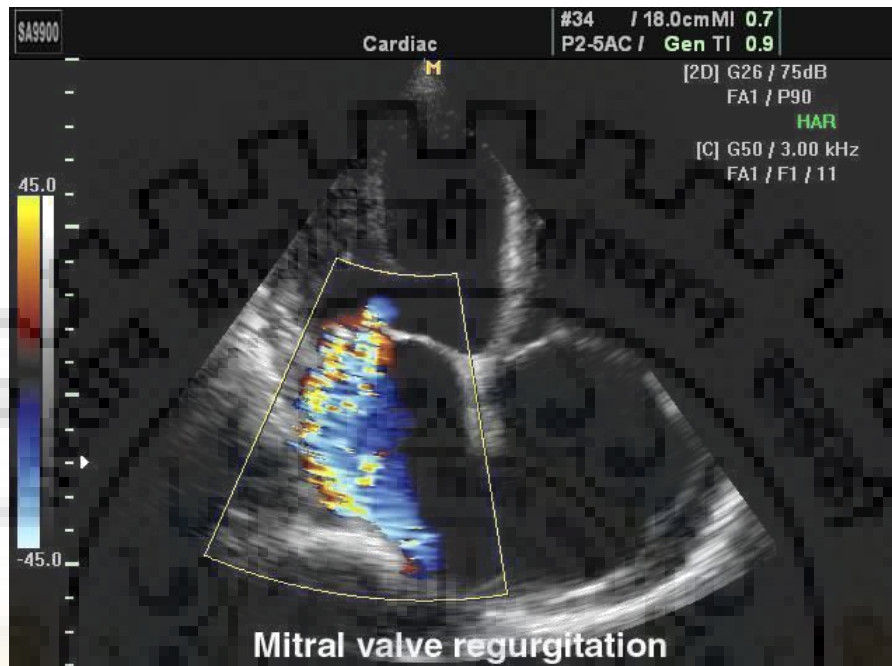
Mitral valve Regurgitation in color Doppler mode [3].
